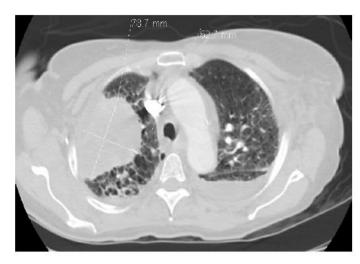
Transverse image of chest CT demonstrating the large 78.7 mm by 62.7 mm lung mass which was found to be adenocarcinoma of the lung.
